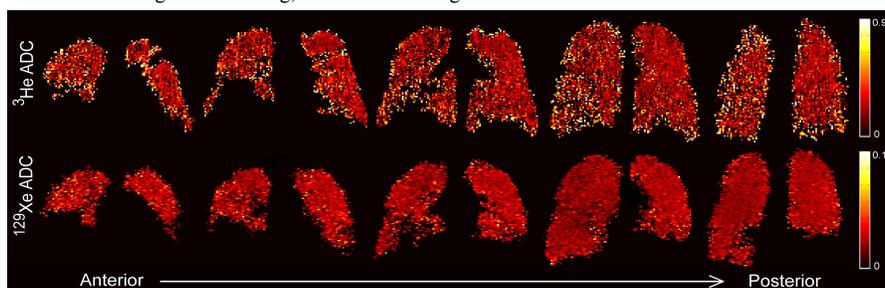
^3He and ^{129}Xe MRI anterior to posterior ADC maps for a representative asthma subject.
